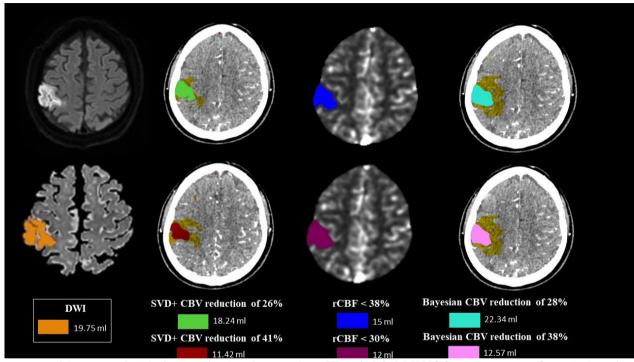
A 74 year-old man with left hemispheric stroke. The initial NIHSS score was 6 and the time between CTP to MRI was 29 min. The infarct core volume was estimated 19.75 ml with DWI-ADC (orange color). The CTA demonstrates occlusion of the right proximal ICA and M3 distal branch of MCA. The infarct core volume was estimated 11.42 ml on SVD+ VITREA CBV reduction of 41% (red color), 18.24 ml on SVD+ VITREA CBV reduction of 26% (green color), 12.57 ml on BAYESIAN VITREA CBV reduction of 38% (pink color), 22.34 ml on BAYESIAN VITREA CBV reduction of 28% (turquoise color), 12 ml on RAPID rCBF < 30% (purple color), and 15 ml on RAPID rCBF < 38% (blue color).
